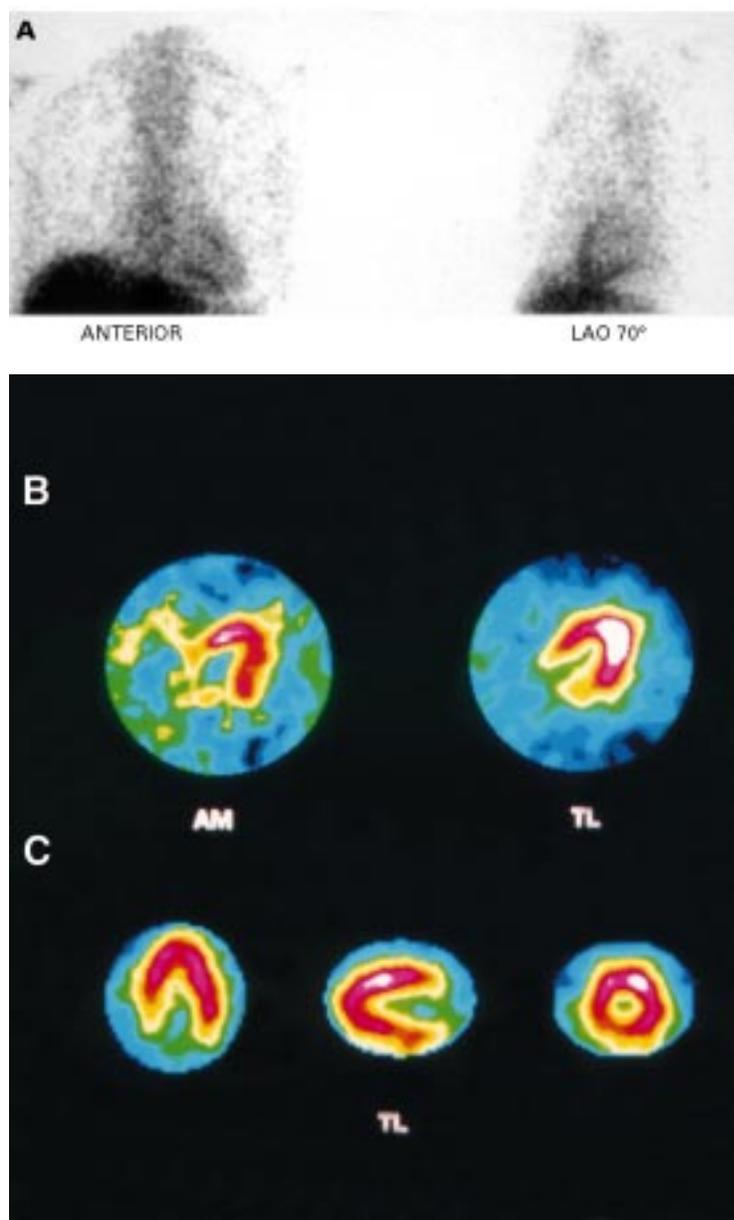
Initial scintigraphy of patient X (periarteritis nodosa), who presented with clinical LV failure (LV ejection fraction = 27%). Significant myocardial AM uptake is observed on the planar anterior view (A), HLR=2. Dual isotope SPECT (corresponding AM/TL slices) shows diffuse AM uptake throughout the left ventricle (B), and normal TL scan (C).
